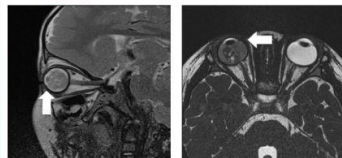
(left) Oblique sagittal T2-weighted MRI image and (right) axial T2-weighted MRI image of a 19-month-old patient with right eye retinoblastoma. The large tumour in posterior aspect of right globe is inseparable with the ciliary body and lens of right eye (arrow), indicative of anterior chamber invasion. The anterior chamber depth of right eye is reduced, which is suggestive of underlying raised intraocular pressure.
